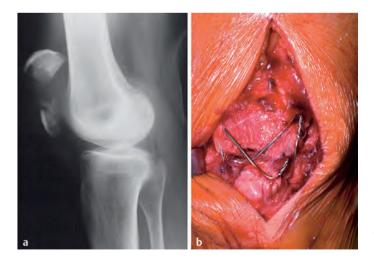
Transverse patellar fracture. a Radiograph. b Intraoperative image of repair with tension banding.
